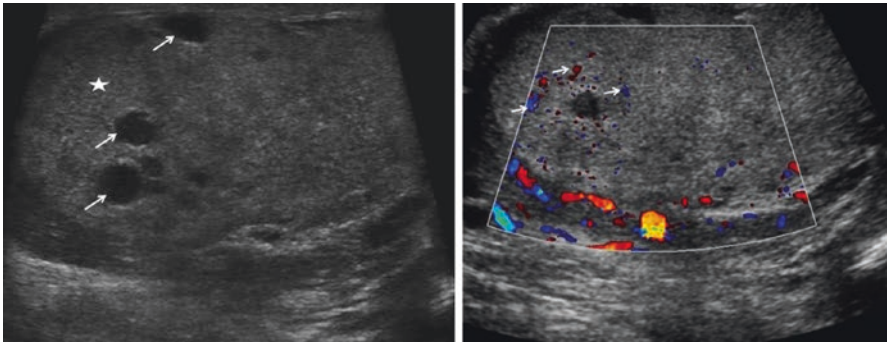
Longitudinal ultrasound image of the right testis. Enlarged upper pole (*star*) and several areas of low reflectivity at the site of trauma (*arrows*) [88]. Doppler image showing ischaemia [88]
